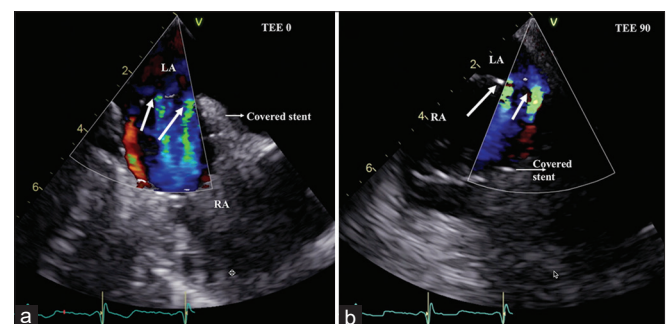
Transesophageal echocardiography with color Doppler in axial view (a) and bicaval view (b) shows two small fabric perforations in the covered stent measuring 2 mm each causing left-to-right shunt from the left atrium to the right atrium. TEE: Transesophageal echocardiography, RA: Right atrium, LA: Left atrium
